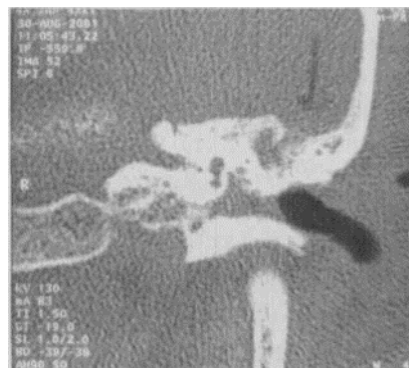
CT cisternography showing defect in tegmen with opacity in mastoid air cells and middle ear.
